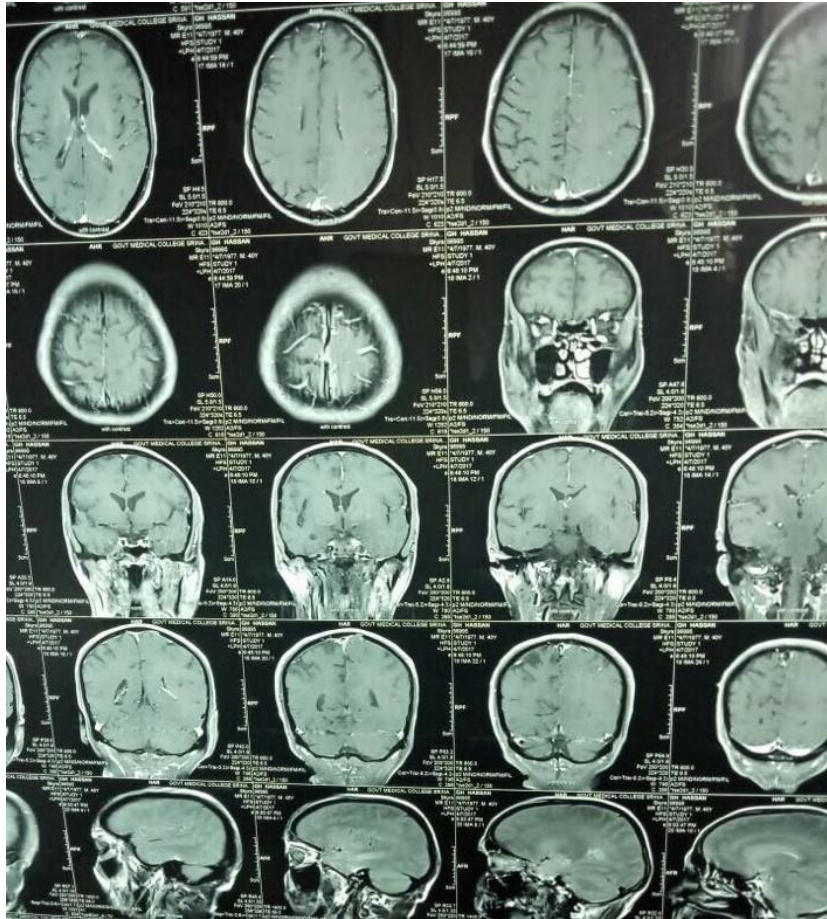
showing initial MRI post contrast images with no significant post contrast enhancement.
